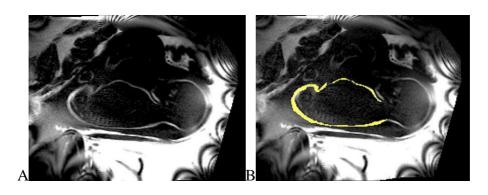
Fetal subcutaneous fat MRI images Uncoloured (A) and coloured (B) sagittal slices through the fetus to show the subcutaneous fat.
